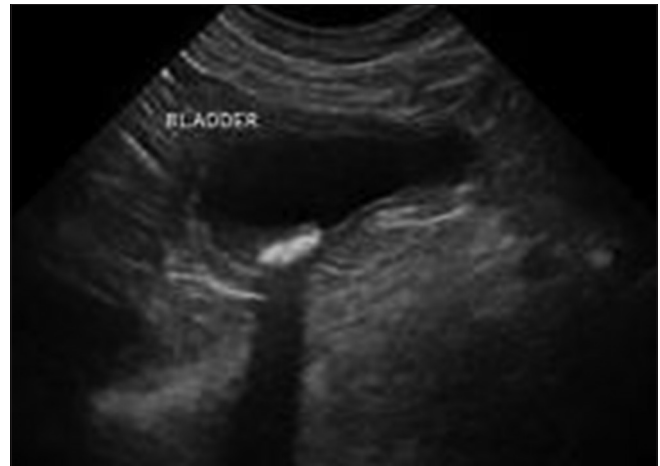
Ultrasound image showing an echo-reflective bladder calculus
